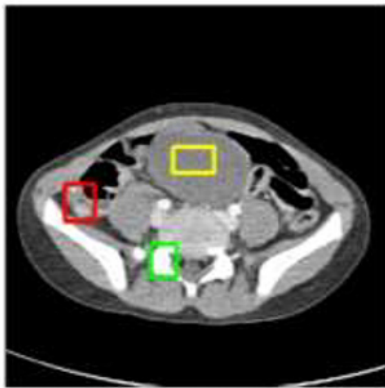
The image at the tolerated noise level of a 25 kg, 5 year-old male patient with appendicitis. The red box marks the appendix. Other regions of interest (ROI) include the bladder (yellow box) and pedicle (green box). In the uniform bladder region, where one typically measures noise in a CT image, the standard deviation (std) is 19 Hounsfield Units (HU), but anatomy in appendix and pedicle ROI's result in std's of 294 HU and 332 HU, respectively, overwhelming the stochastic noise component.
